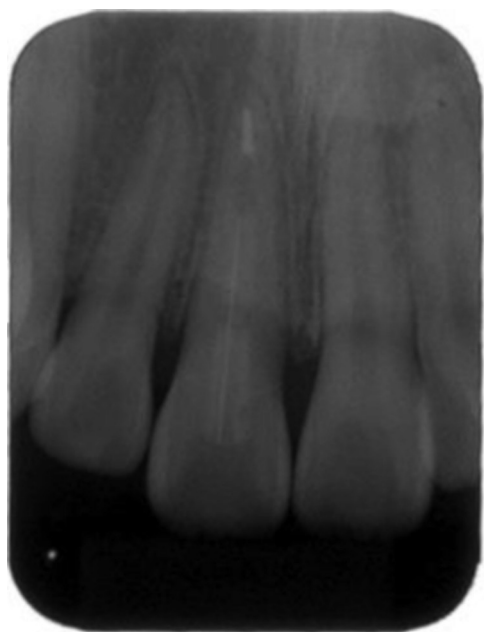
Radiographic follow-up 7 days after surgery and fragment reattachment.
